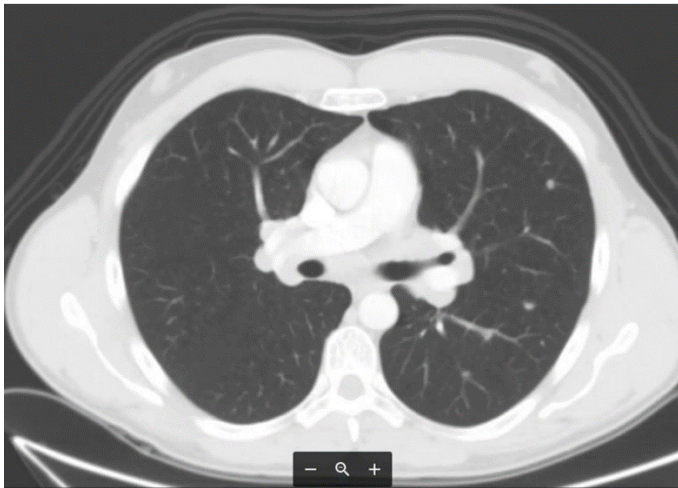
Chest abdomen pelvis Computed Tomography (CT) scan.
